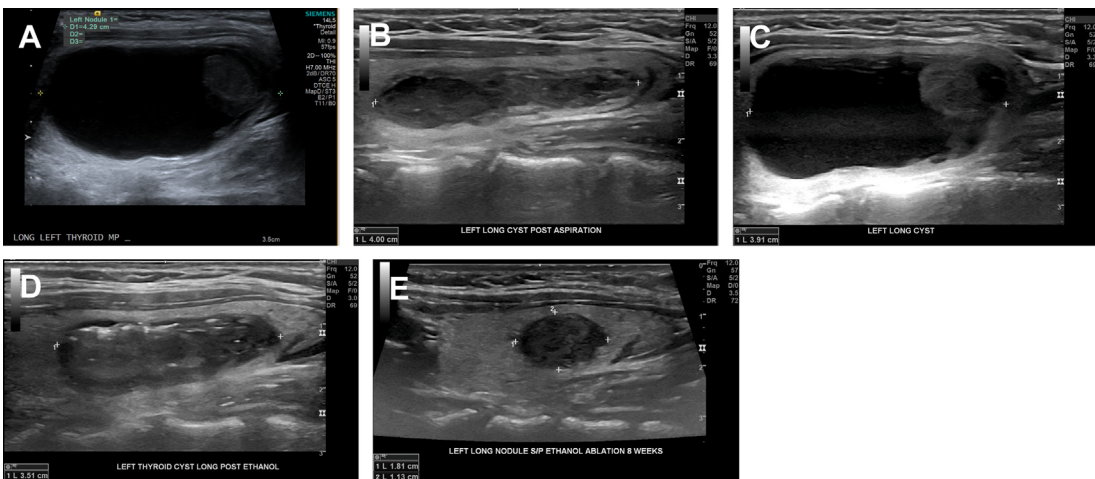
Case of a 37-year-old female with cosmetic and compressive symptoms due to left-sided predominantly cystic nodule (A) Initial ultrasound evaluation (B) Status post simple aspiration (C) Reaccumulation of cystic fluid at 1-month follow-up (D) Immediately post ethanol aspiration (E) sustained benefit at 8-weeks post ethanol ablation.
